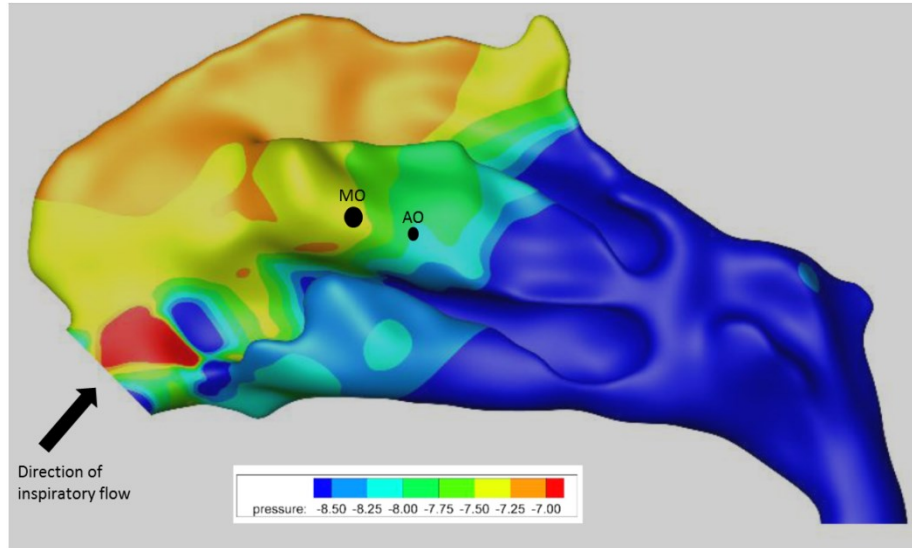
The pressure drop in the left nasal cavity based on the same CT scan data as the idealised sinus model. The airway boundary is colour-coded to indicate the local static pressure for a flow rate of 5 l/min. The nasal vestibule is not shown and the external reference pressure is set to zero. The large black spot indicates the position of the maxillary ostium. The smaller black spot AO indicates the position of the accessory ostium. Pressure scale in Pa. Figure provided by Dr D. J. Taylor, Imperial College London.
